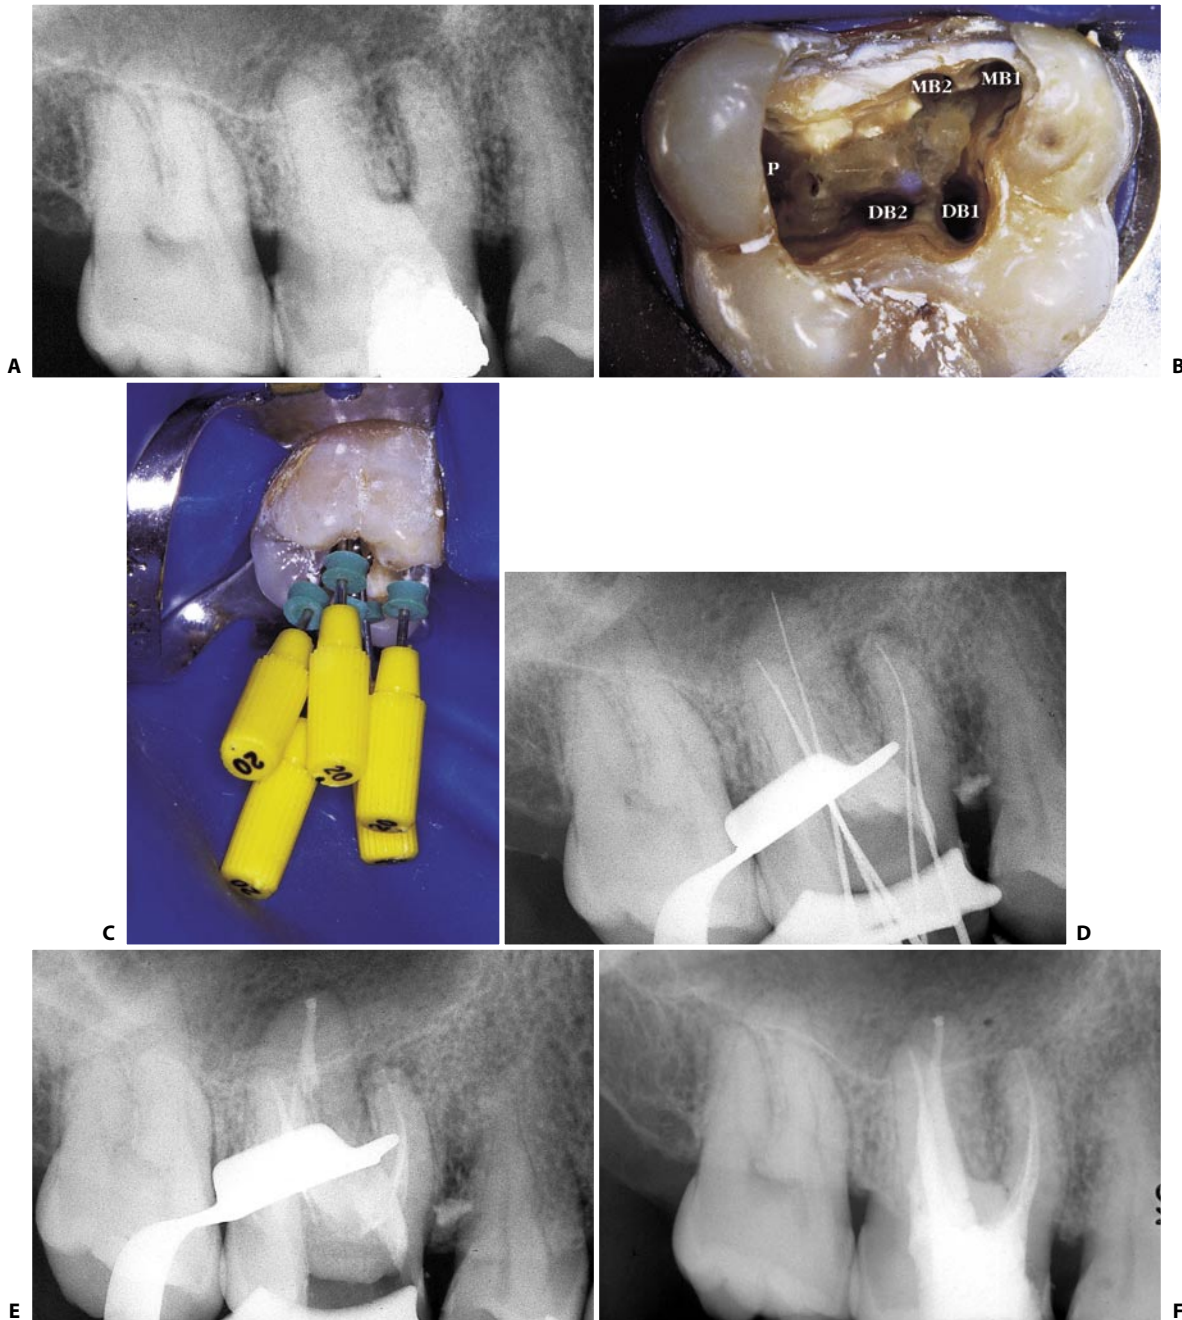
A. Preoperative radiograph of an upper right first molar with five canals, two of which are in the distobuccal root. B. The access cavity reveals the five openings after the canals have been cleaned and shaped. C. Five instruments introduced into their respective five canals (the 5 instruments have been introduced in each canal only for documentation, and not to check 5 working lengths at the same time!). D. Intraoperative radiograph. E. Radiograph of the apical compaction. The five canals don't seem to have independent foramina. F. Postoperative radiograph.
